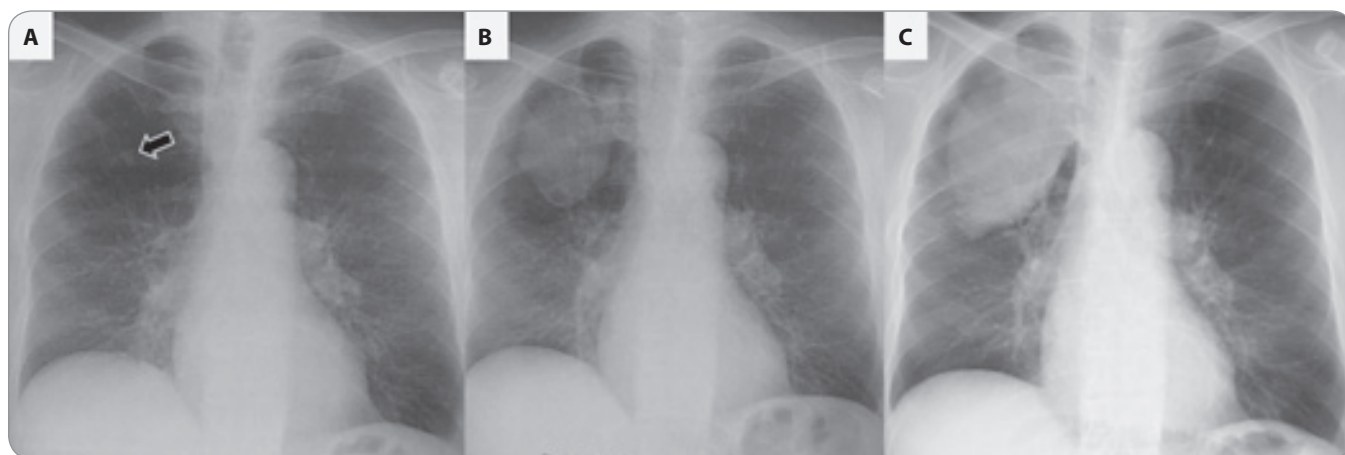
A chest radiograph taken when shortness of breath increased and bloody sputum appeared showed an 11 × 9 mm nodule in the right upper lung field (A). The nodule grew to 89 × 60 mm 9 weeks after the nodule was discovered (B), and the size of the nodule taken 11 weeks after the nodule increased to 102 × 68 mm (C). Fluorodeoxyglucose-positron emission tomography / computed tomography (FDG-PET/CT) performed before the start of treatment showed significant uptake of FDG in most part of the mass (D).
